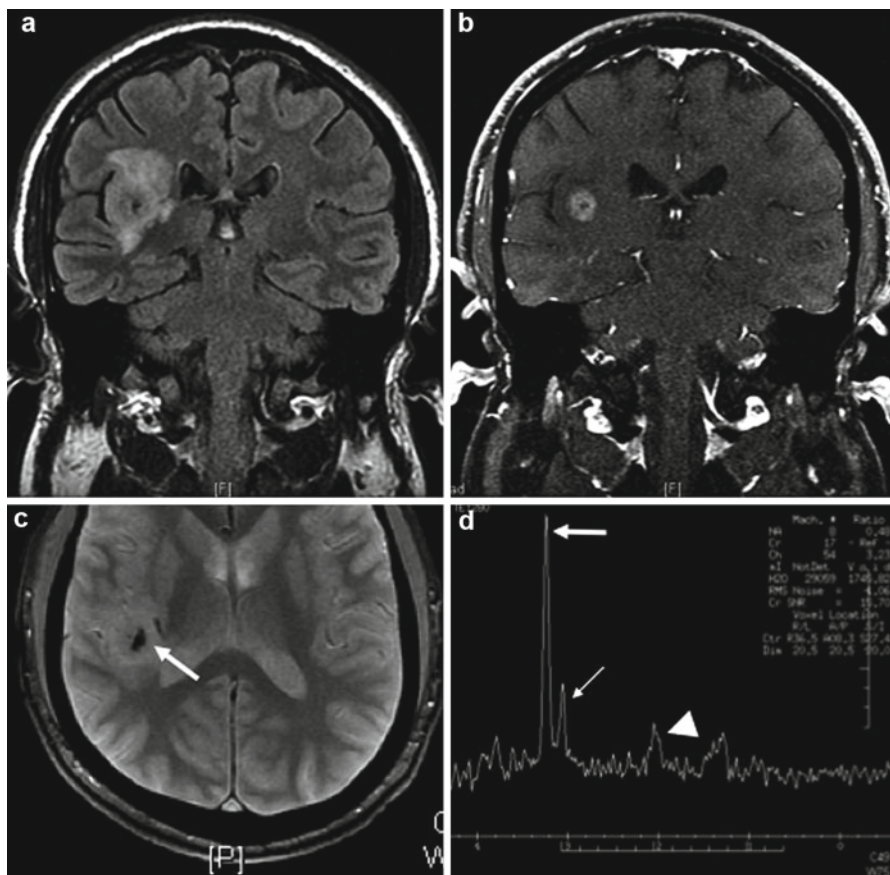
Example of a grade III astrocytoma. (a) Coronal T2 FLAIR showing mass-like infiltrative T2 signal abnormality involving the insular cortex and subcortical white matter. (b) Post-gadolinium T1WI demonstrates central enhancement. (c) Foci of internal calcification are noted on the gradient-echo image (*arrow*). (d) MRS demonstrates an elevated choline to creatine (Cho:Cr) ratio of 3:1 characteristic of malignancy and a marked reduction of NAA, a normal neuronal marker (Cho, *thick arrow*; Cr, *thin arrow*; NAA, *arrowhead*)
